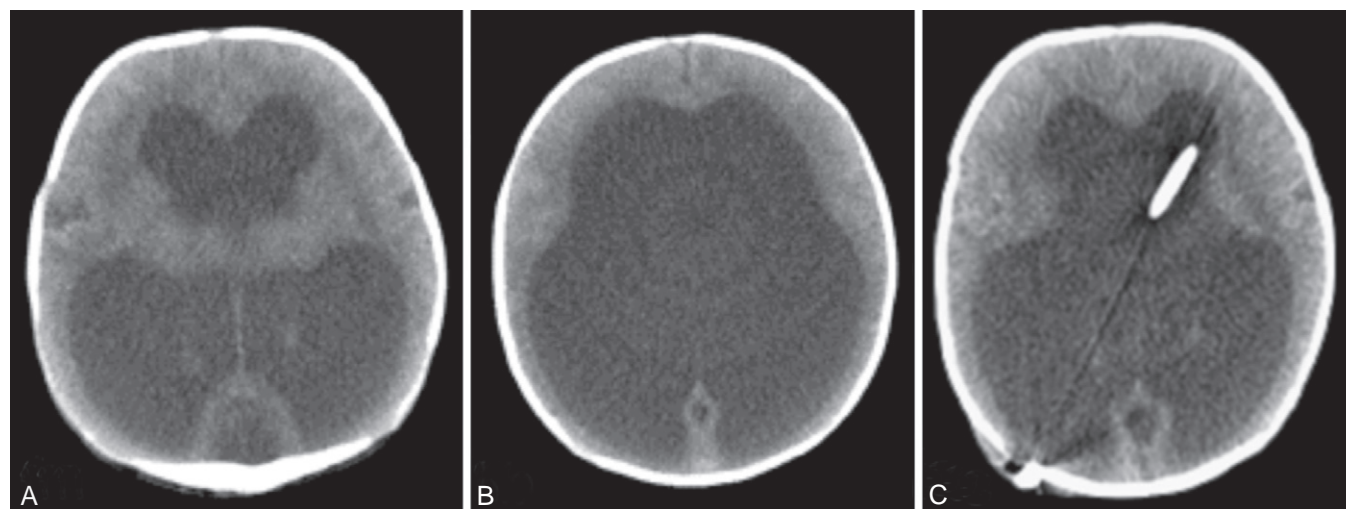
One-day-old girl with severe obstructive hydrocephalus secondary to congenital aqueductal stenosis. A and B, Head computed tomography (CT) scan showing severe ventriculomegaly. C, Head CT scan 1 day after shunt placement.
